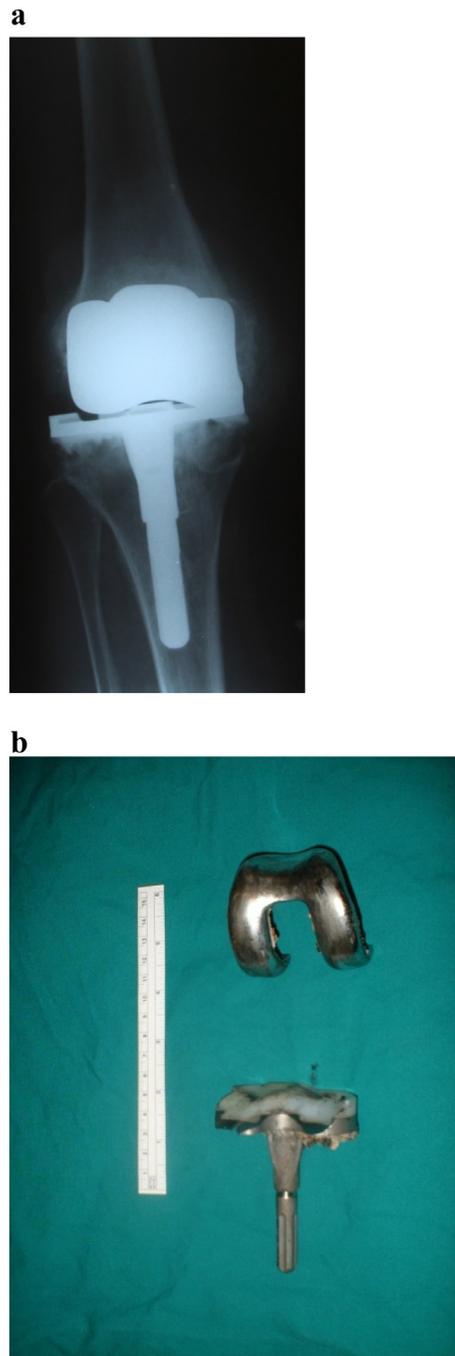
a. Anteroposterior radiographs of a right total knee arthroplasty showing severe polyethylene wear and structural damage of the insert at 12-year follow-up. b. Photograph showing the retrieved damaged implants during surgery.
